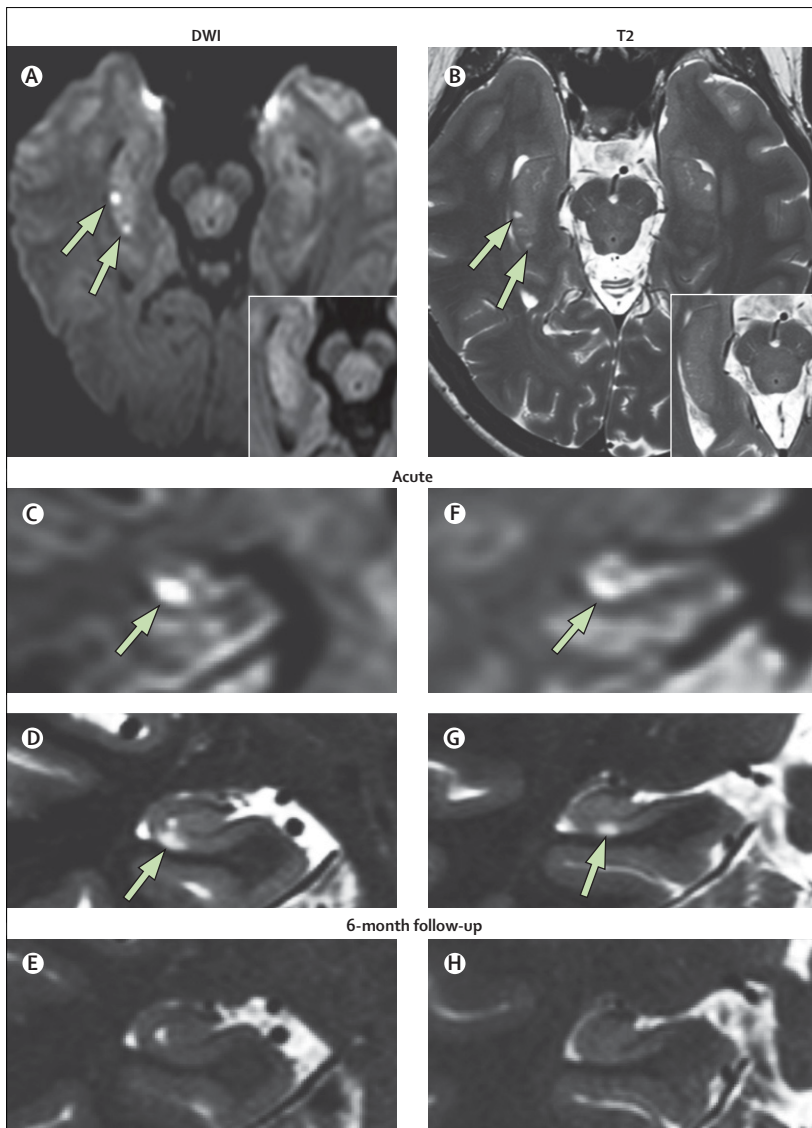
MRI findings in TGA
